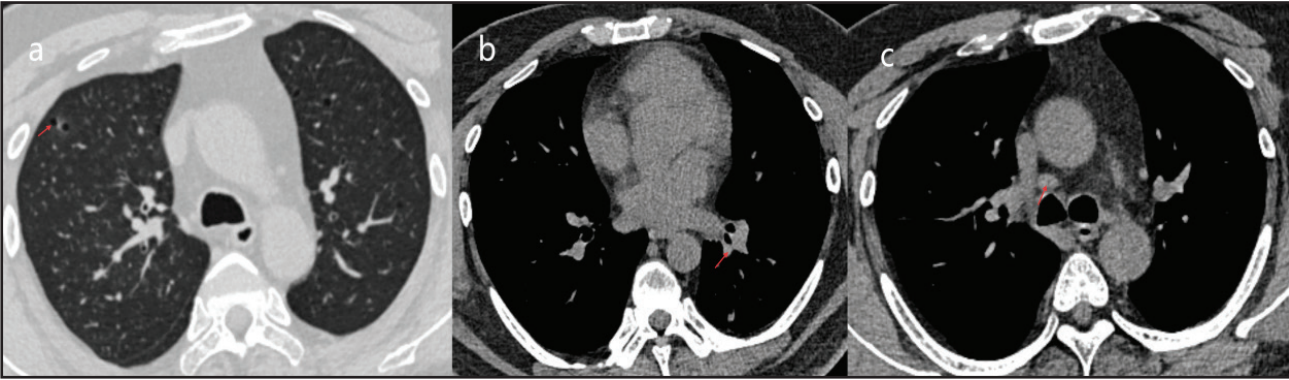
Chest CT (April 15, 2026). (a) Lung window showing stable bilateral small cystic lesions. (b and c) Mediastinal window showing further reduction of the left lower lobe mass, with essentially stable mediastinal lymph nodes.
